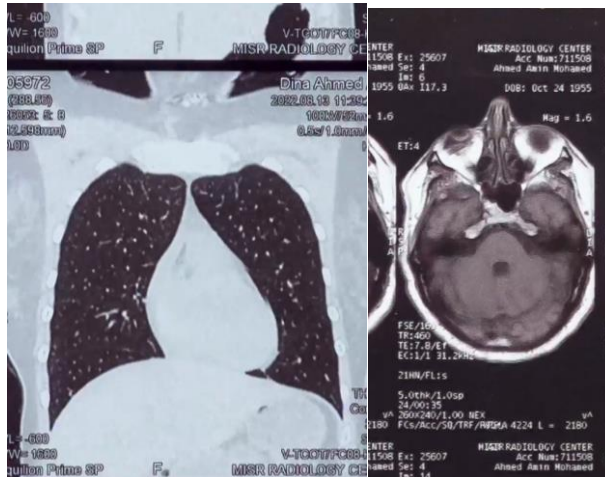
CT exercise still from Dina Amin (2022). Figure 84. MRI exercise still from Dina Amin (2022).
